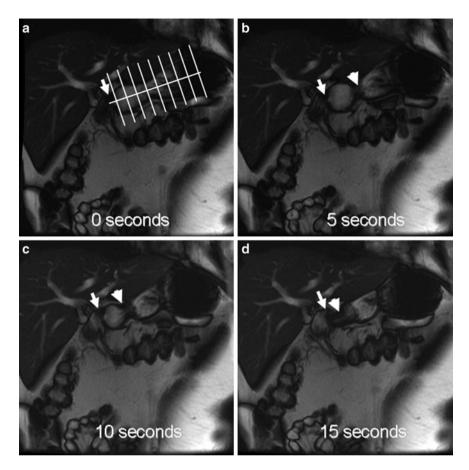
Time sequence of 2D oblique coronal plane MR images (multiphase 2D FISP sequence) of the stomach in a patient with rapid gastric emptying. For clarity, only every fifth image (i.e., at 5-s intervals) is shown. The longitudinal axis and perpendicular planes used to measure gastric dimensions are shown in Panel (a). Panels (b) and (c) depict a propagating contraction (*arrowhead*), which distends the antral bulb proximal to the pylorus (*arrow*). Panel (d) shows a terminal antral contraction (*arrowhead*) with filling of the duodenal bulb distal to the pylorus (*arrow*), which contrasts to the typical pattern wherein the pylorus is closed ahead of a terminal antral contraction. Reproduced with permission from Bharucha AE, Manduca A, Lake DS, Fidler J, Edwards P, Grimm RC, Zinsmeister AR, Riederer SJ. Gastric Motor Disturbances In Patients With Idiopathic Rapid Gastric Emptying. Neurogastroenterol Motil 2011;23(7):617–e252
